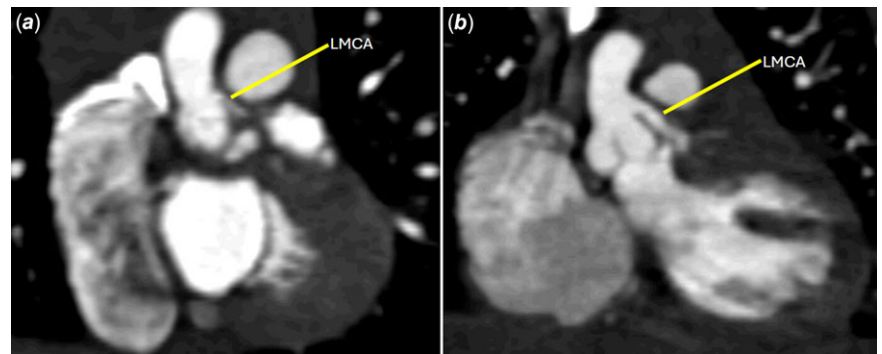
Computed tomography angiography coronal images demonstrating the anatomy of the left main coronary artery (LMCA) both post-left thoracotomy coarctation repair (a) and post-coronary ostioplasty (b).
